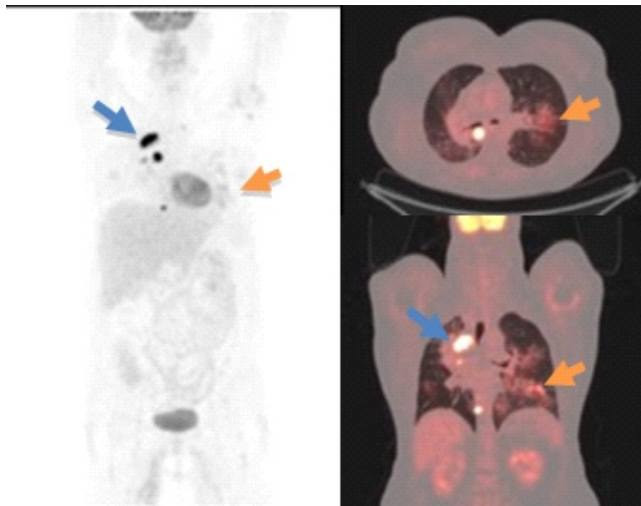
A 59 year old woman with right lung carcinoma. Fluorine-18-FDG PET/CT: expected and typical pathological neoplastic uptake (blue arrow); unexpected and atypical presence of diffuse ^{18}F -FDG uptake in the right lung lobe (green arrow) due to infection. Final diagnosis: lung carcinoma and simultaneous aspergillosis.
